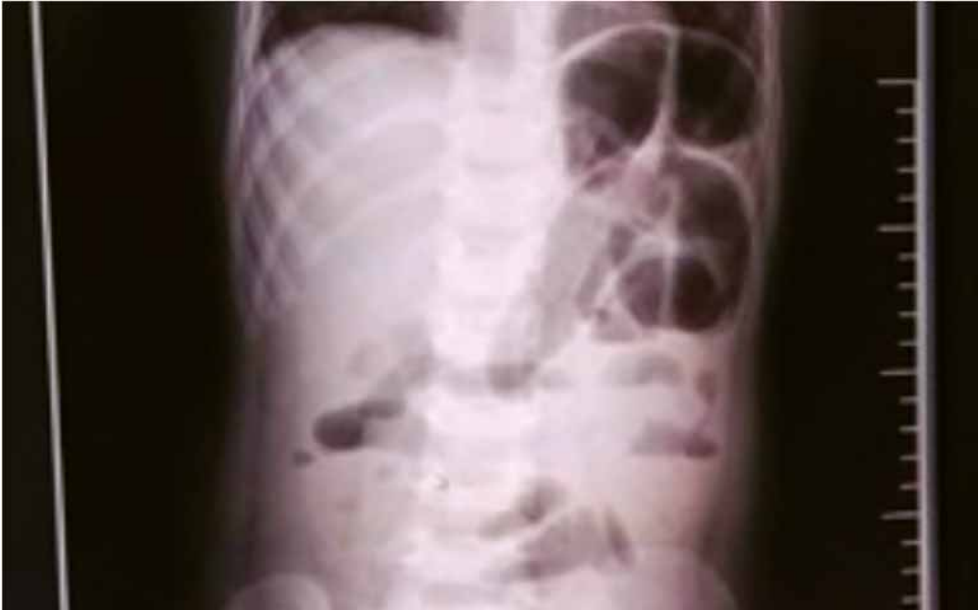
Abdominal X-ray showing air-fluid level or gas deposition on the right lower quadrant abdomen (Prof. Stefan Durdik, MD, PhD., Department of Surgical Oncology, St. Elizabeth Hospital, Medical School of Comenius University, Bratislava)
